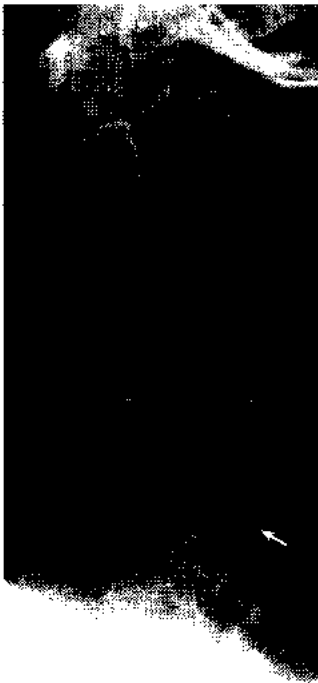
Lateral radiograph revealing unilateral facet dislocation of C5 on C6. The superior facet of C6 has moved posteriorly and superiorly to the inferior facet of C5. There is almost no translation of the vertebral bodies.
